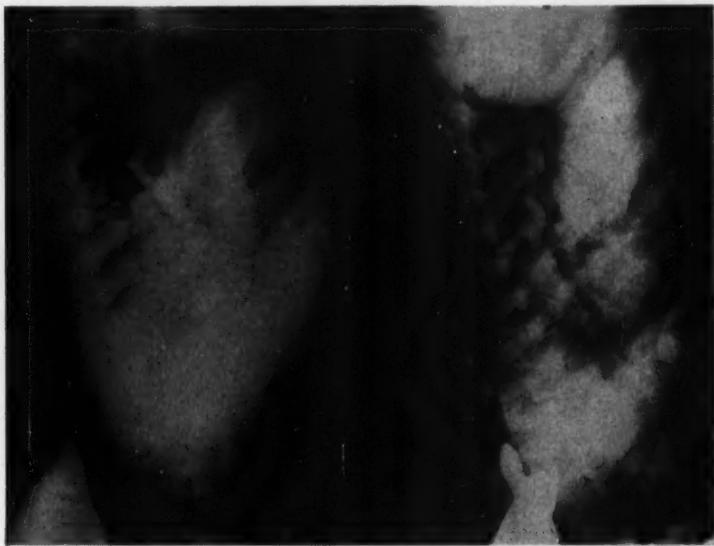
& 1B. Case No. 1. Right posterior oblique x-ray views of the heart and great vessels taken following the injection of dye.
